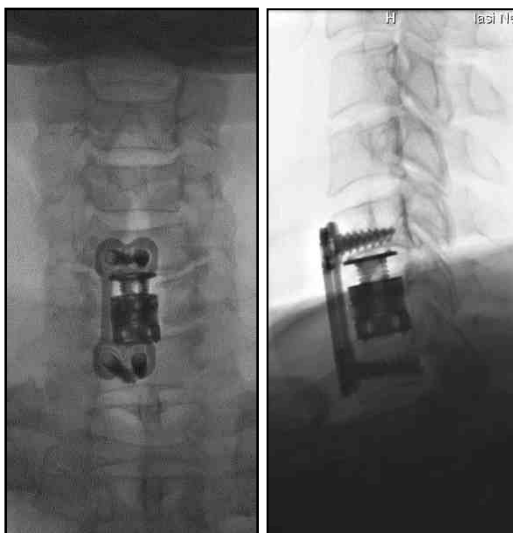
X-ray showing expandable cervical cage properly implanted and a good alignment of cervical spine by anterior cervical plate fixation
